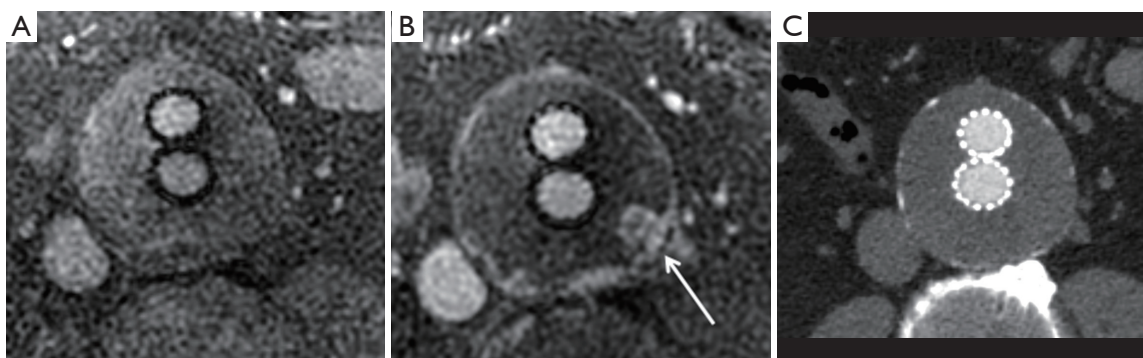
MRA for evaluation of postoperative aorta in a 72-year-old male with progressively enlarging aneurysm sac status post EVAR for abdominal aortic aneurysm. (A) Pre- and (B) post-contrast MRA of the aneurysm sac demonstrating type II endoleak (white arrow); (C) outside CTA performed at this same level with decreased conspicuity of the endoleak. Delayed imaging was not performed. MRA, magnetic resonance angiography; CTA, computed tomography angiography; EVAR, endovascular aneurysm repair.
